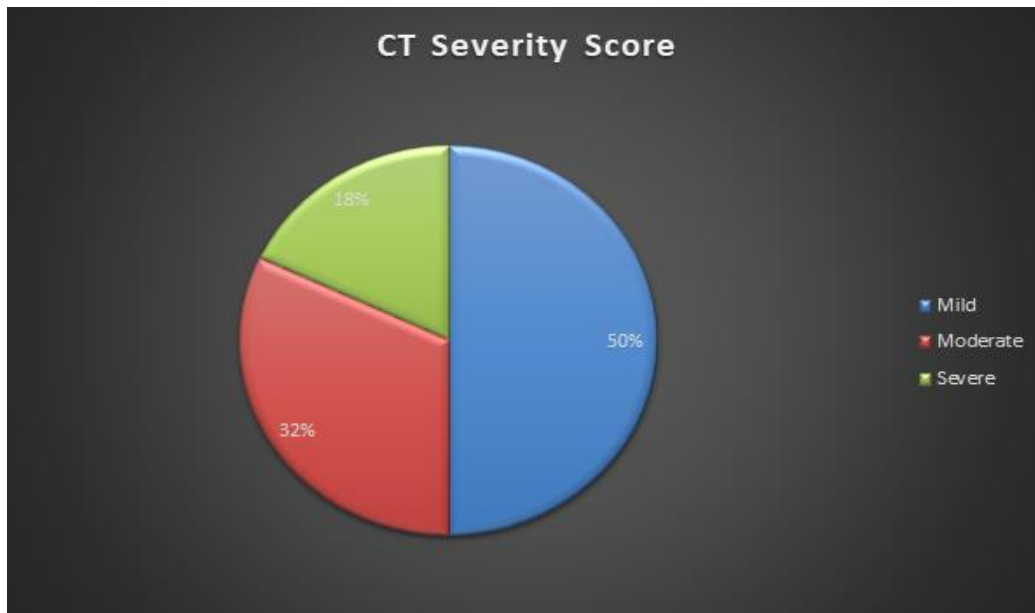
Distribution of CT Severity Score in Covid 19 patients.
